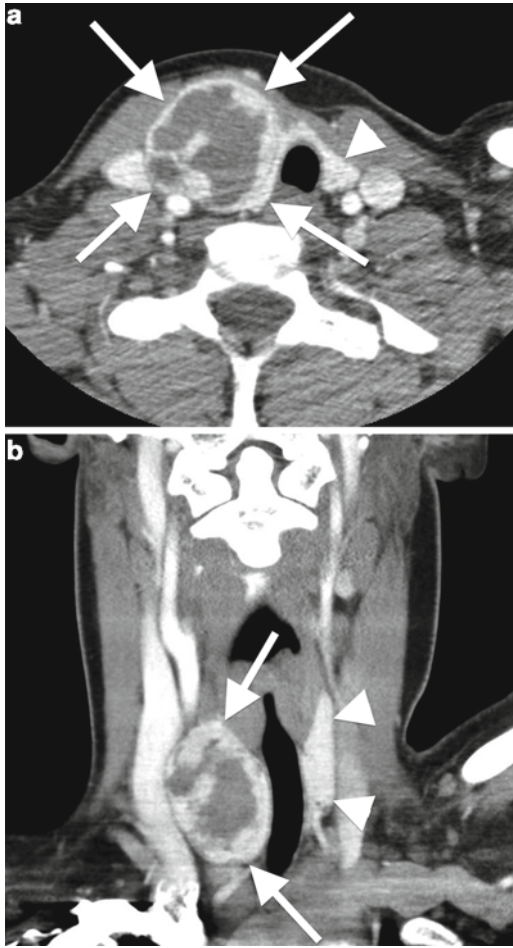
Degenerating nodule. Axial (a) and coronal (b) enhanced CT in a 11-year-old boy with a long-standing thyroid mass show a nonspecific, partially enhancing cystic mass (*arrows*) found to be a degenerating nodule on pathology. Note the normal left thyroid lobe (*arrowheads*).
